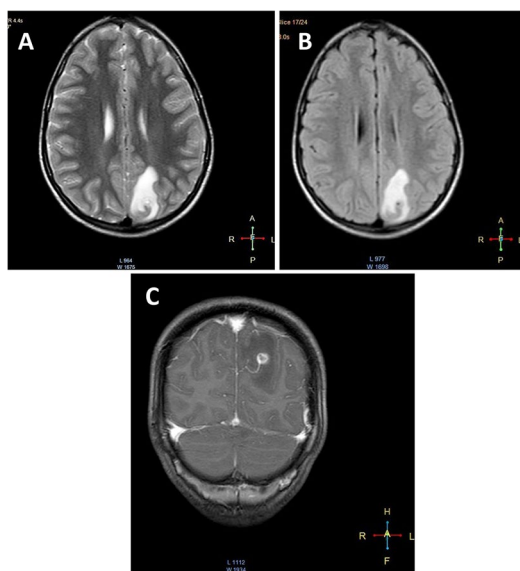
T2 (A), FLAIR (B) and CISS sequence (C) shows solitary cysticercal lesion in occipital lobe in vesicular nodular stage with perilesional oedema
